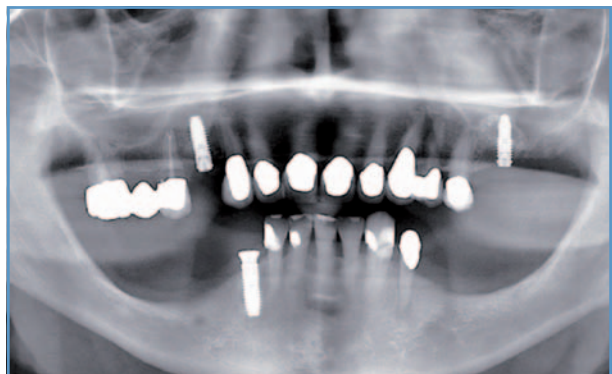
X-ray image six months postoperatively, prior to exposure and final treatment: good osseointegration of the implants, residual granules at site 26 visible.
